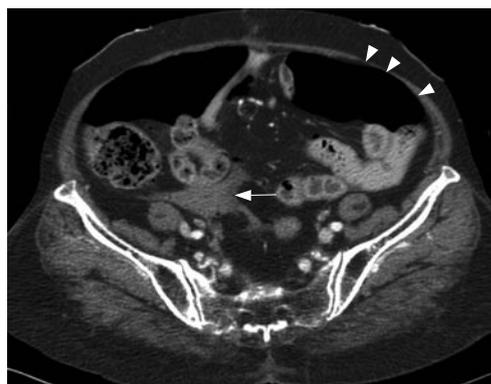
Abdomino-pelvic CT at pelvis level showing a large amount of extraluminal air (arrow heads) mixed with a complicated collection of fluids, probably primary extraluminal feces (arrow).
